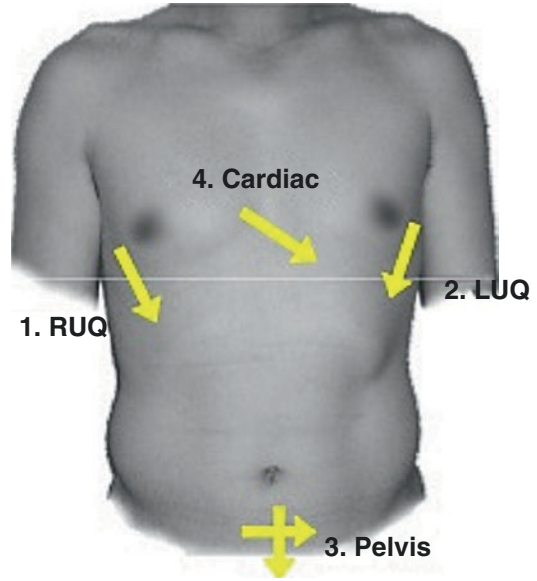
FAST – Location of probe placement for the trauma examination (u.surgery. (2009). Focused Abdominal Sonography for Trauma [PowerPoint slides]. Retrieved from <http://www.slideshare.net/u.surgery/focused-abdominal-sonography-for-trauma>)
